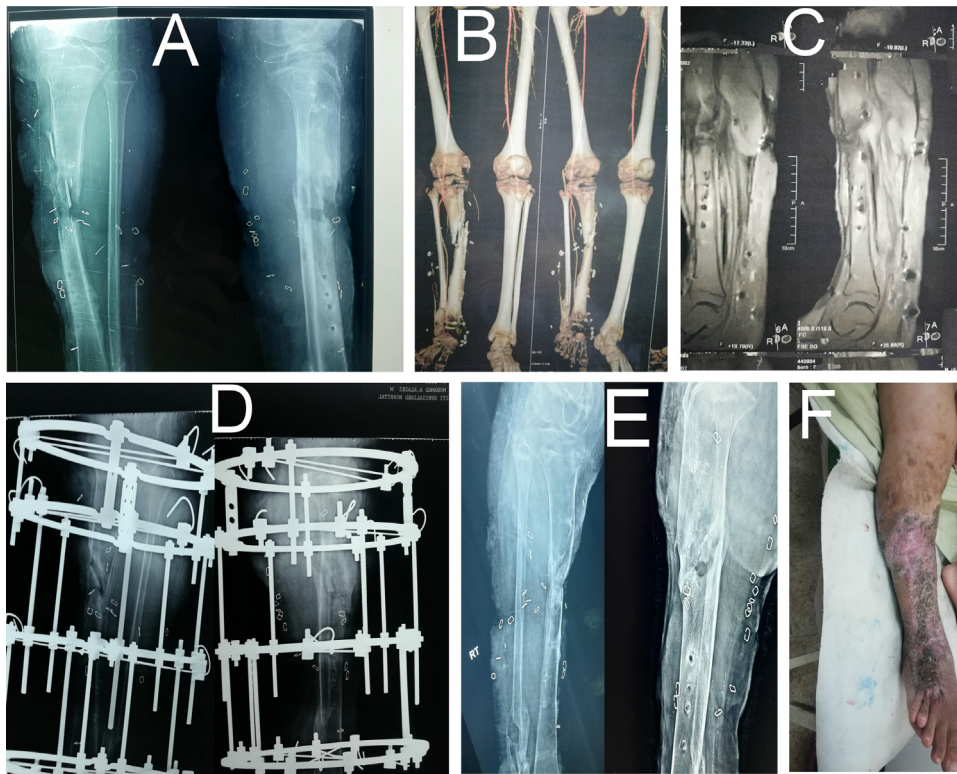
A. Plane X-rays Antero-posterior and lateral views show site of infected nonunion after fixator removal. B. C.T.angiography of the injured lower limb after fixator removal show adequate blood supply of the limb. C. C.T. Shows the site of infected non union and the sequestrum. D. Plane X-rays show application of Ilizarov external fixator with compression distraction technique. E. Plane X-rays Antero-posterior and lateral views show union had achieved and the apparatus was removed. F. Clinical photos from medial and lateral side show the extent of the skin graft and clinical outcome.
